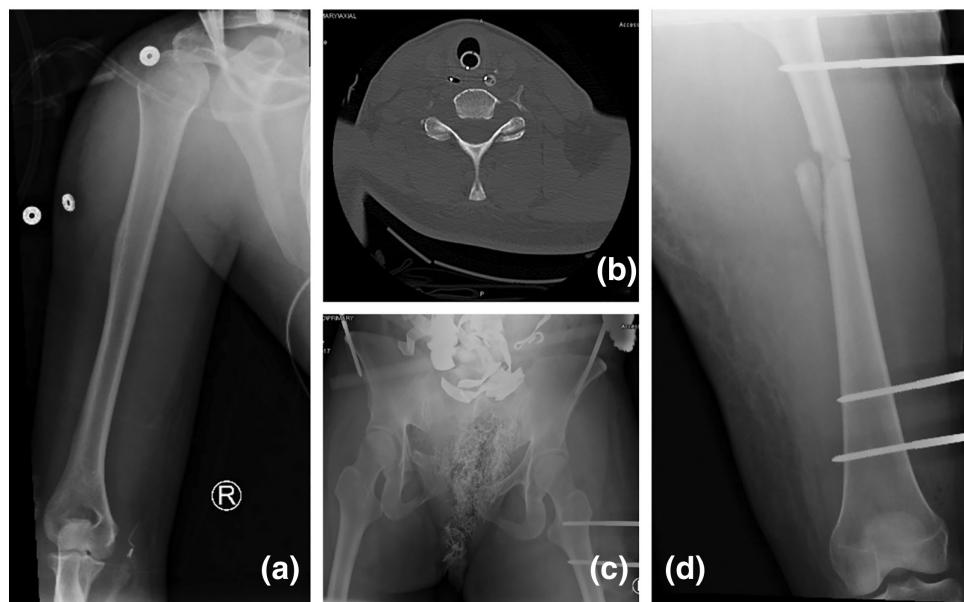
Bone fracture radiographs.
